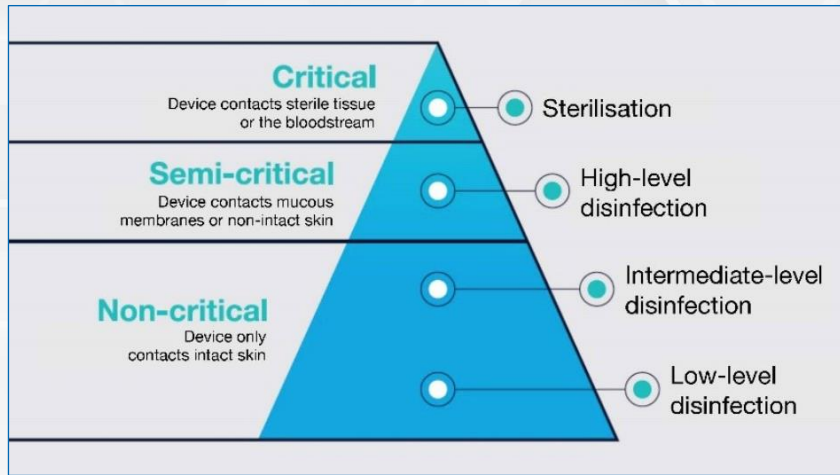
Image Source: <https://www.hospitalhealth.com.au/content/clinical-services/sponsored/ultrasound-infection-prevention-workflow-standardisation-unlocking-risk-management-476272533>
